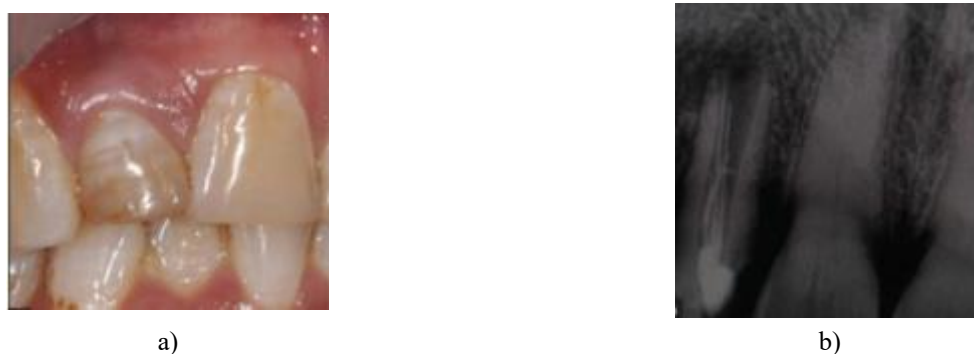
(a) Fractured maxillary left central incisor; (b) cross-sectional view; (c) extracted tooth; (d) implant placed in extraction socket; (e) radiograph after implant placement
